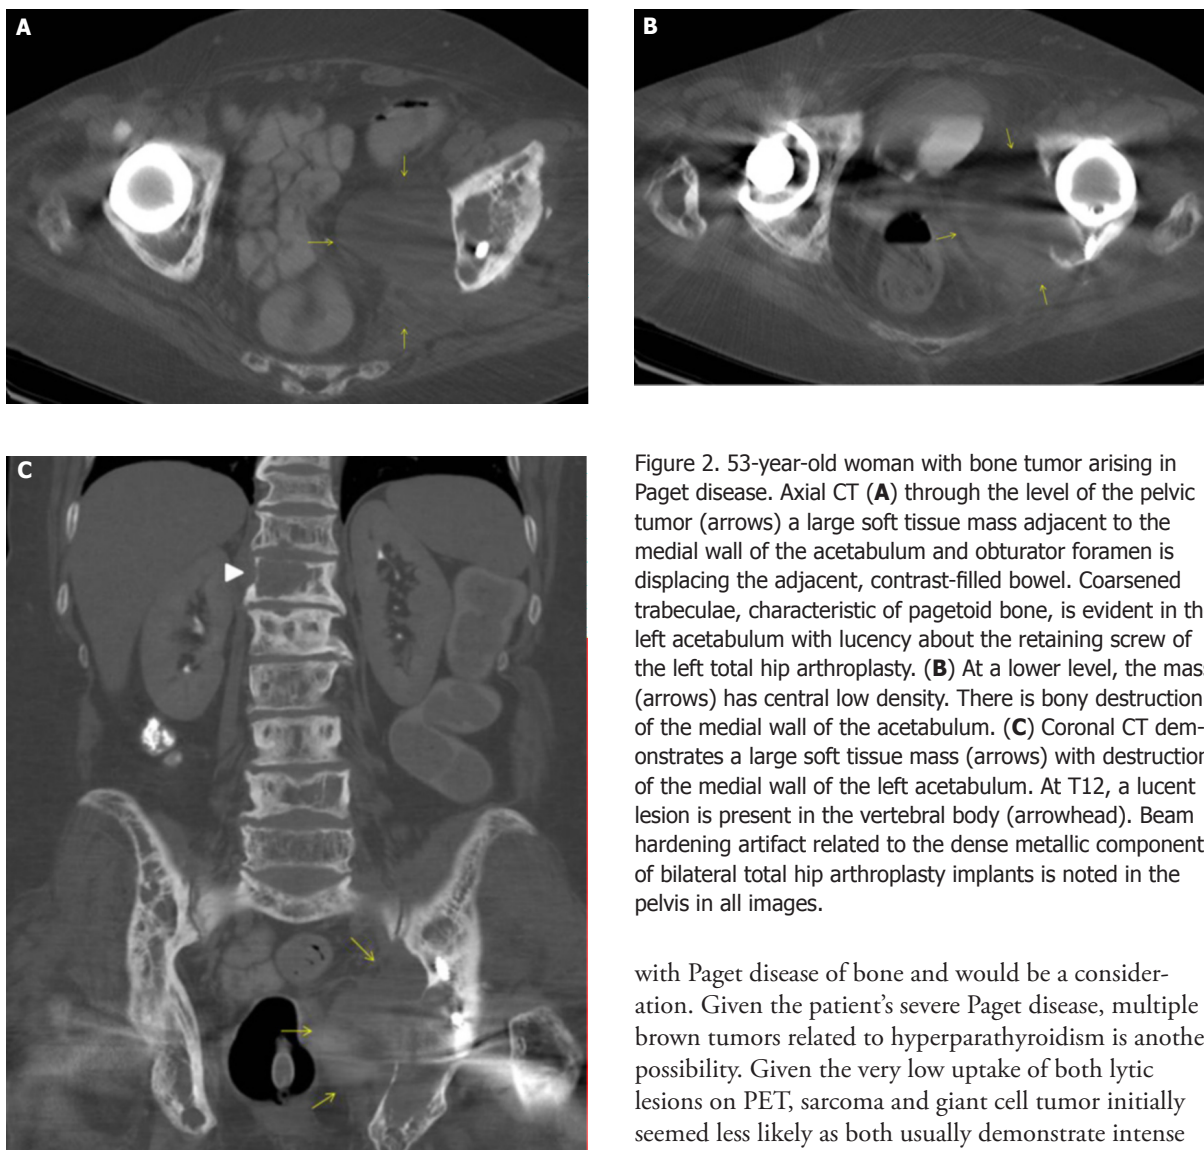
53-year-old woman with bone tumor arising in Paget disease. Axial CT (A) through the level of the pelvic tumor (arrows) a large soft tissue mass adjacent to the medial wall of the acetabulum and obturator foramen is displacing the adjacent, contrast-filled bowel. Coarsened trabeculae, characteristic of pagetoid bone, is evident in the left acetabulum with lucency about the retaining screw of the left total hip arthroplasty. (B) At a lower level, the mass (arrows) has central low density. There is bony destruction of the medial wall of the acetabulum. (C) Coronal CT demonstrates a large soft tissue mass (arrows) with destruction of the medial wall of the left acetabulum. At T12, a lytic lesion is present in the vertebral body (arrowhead). Beam hardening artifact related to the dense metallic components of bilateral total hip arthroplasty implants is noted in the pelvis in all images.
